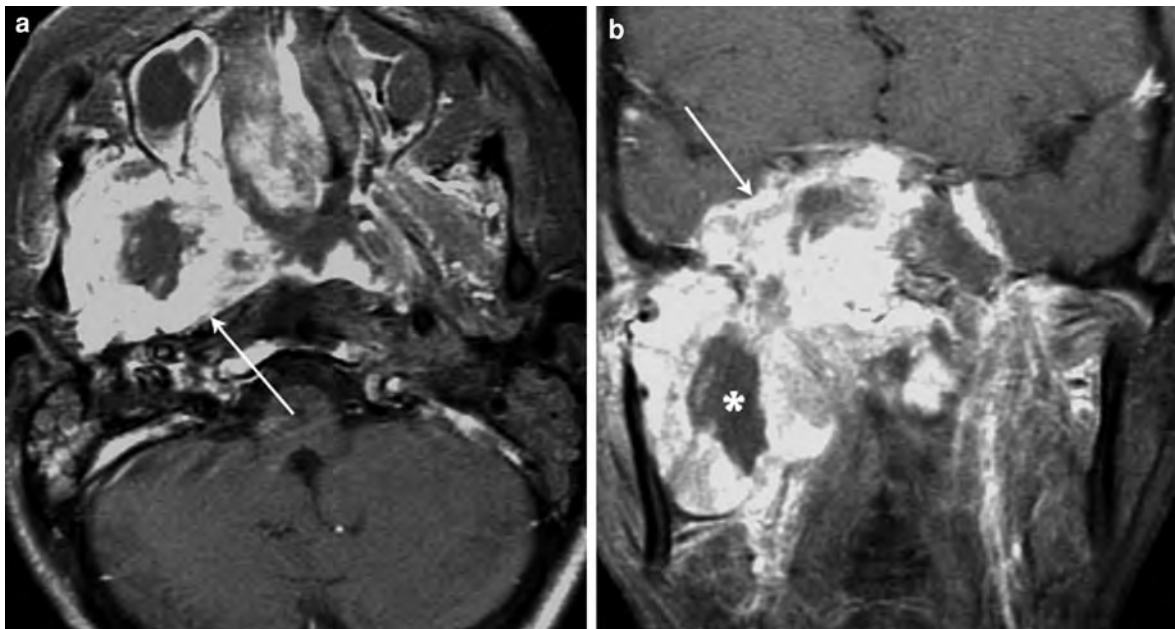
Radiation associated tumour. a Axial contrast-enhanced fat-saturated T1-weighted MR image shows a large necrotic tumour in the right masticator space (*arrow*), in a patient who completed radiotherapy for right-sided nasopharyngeal carcinoma 9 years ago. b Coronal contrast-enhanced
